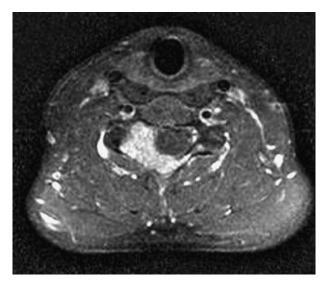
T1-weighted axial magnetic resonance imaging with gadolinium demonstrating a homogenous pattern of enhancement in the C6 lamina and right lateral mass.
